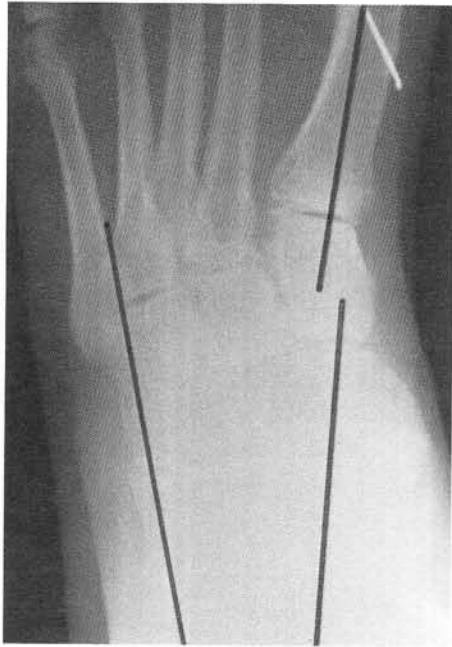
Long-term follow-up radiograph taken in a weight-bearing relaxed position 13 months postoperatively. Note the excellent alignment of the subtalar and midtarsal joint complexes. The patient had previous correction of a hallux abductus valgus deformity prior to the rearfoot fusion. Although not appreciated on this radiograph, the patient had significant forefoot varus not reduced at the time of surgery. An ankle arthroplasty was also performed.
